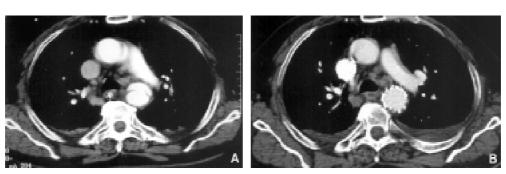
A less invasive technique: (A) isthmic injury with localized dissection and (B) endovascular exclusion showed with CT scan.
